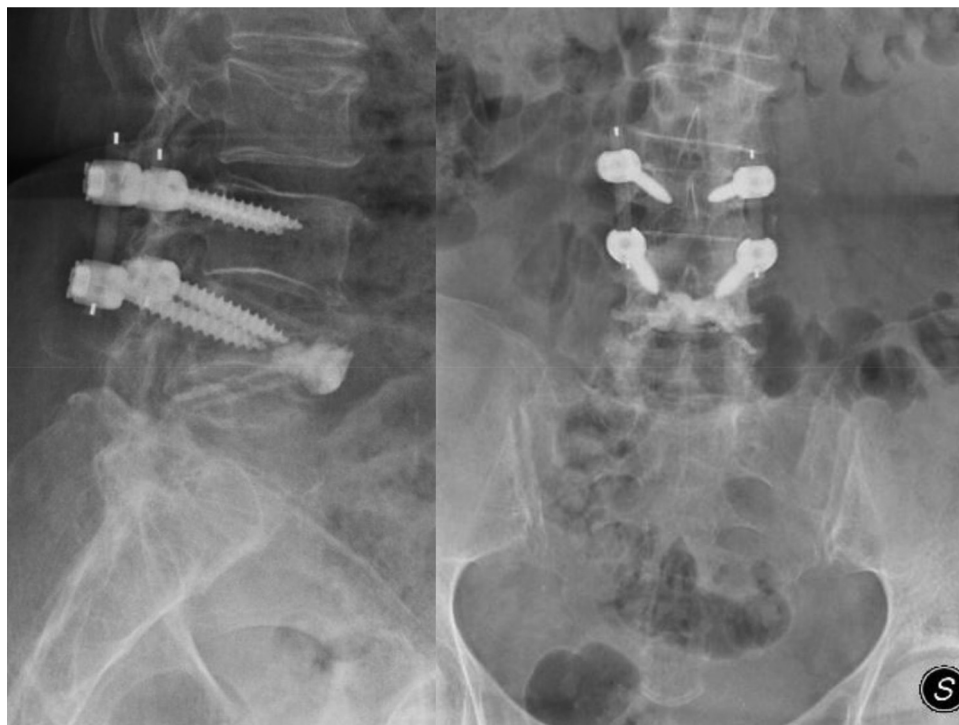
Post-operative x-ray control at 3 days later.
